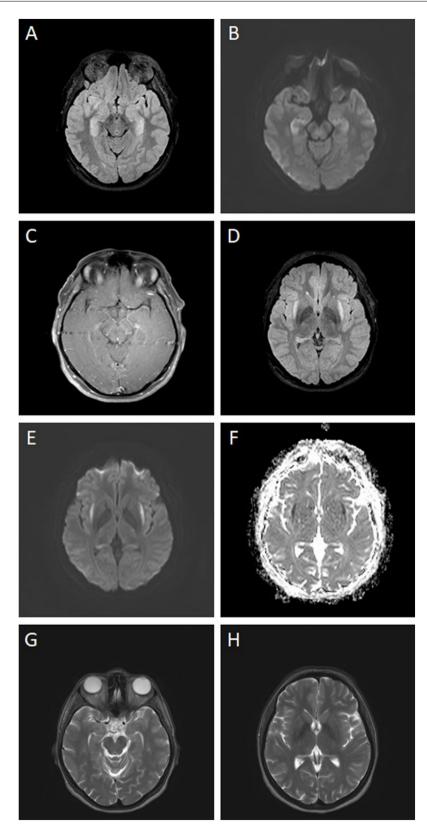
Contrast-enhanced brain MRI study performed at disease onset, showing bilateral hippocampal hyperintensities on T2/FLAIR sequences (A), restricted diffusion (B), and lack of contrast uptake (C). The study also revealed hyperintense lesions in the external capsules on T2/FLAIR sequences (D), with restricted diffusion (hyperintense on diffusion-weighted imaging [E] and hypointense on the apparent diffusion coefficient map [F]). Contrast-enhanced brain MRI study performed at 8 months of follow-up, showing resolution of T2 hyperintensities in the hippocampi (G) and external capsules (H).
